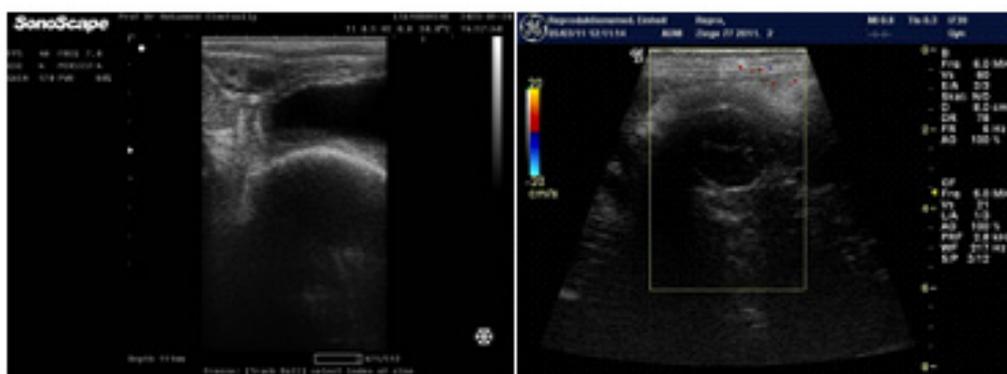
Representation of the ultrasound beam. Left panel: Linear array, and right panel: Convex array.
